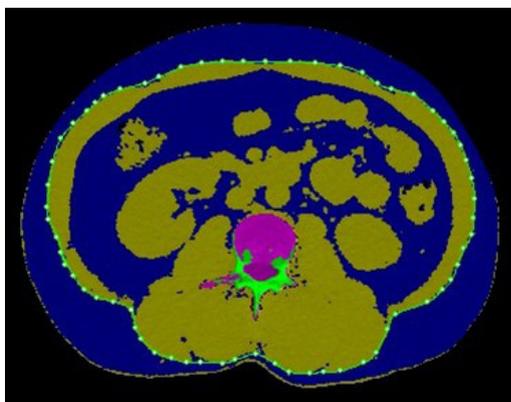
Measurement of abdominal fat by Mindways QCT software. The blue color represents the fat, and the yellow dashed line depicts the abdominal wall. The fat inside this wall is visceral fat (VAT), while the fat outside the wall is subcutaneous fat (SAT). Total fat area (TAT) = VAT + SAT. QCT, quantitative computed tomography.
